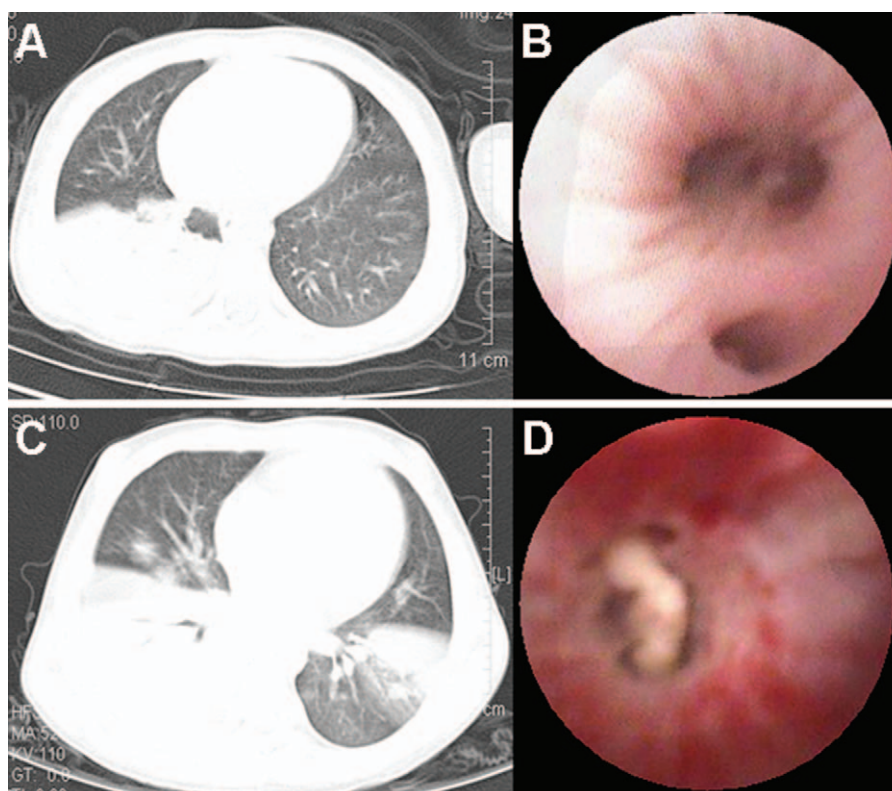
Imaging features. A GMPP patient under CT scanning of the chest (A) and imaging under FOB (B). A RMPP patient under CT (C) and FOB (D).
